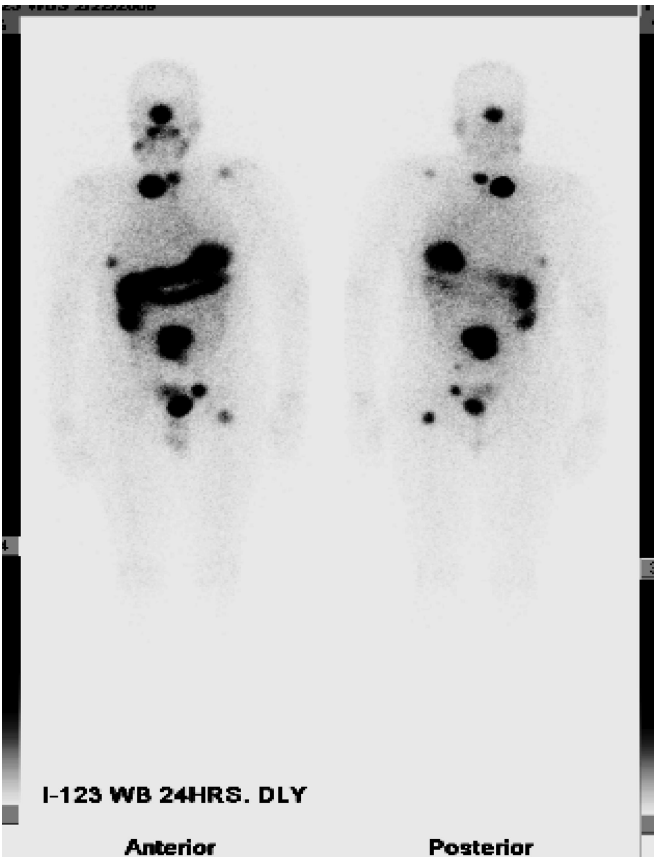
rhTSH-stimulated ¹²³I DxWBS scan in a 49-year-old man (case number 7, Table 3) showing abnormal uptake consistent with widespread skeletal metastases involving the skull, T2 vertebral pedicle, third right rib (with soft-tissue component seen on corresponding CT scan), left seventh rib, dorsal spine, left shoulder, lumbar spine, sacrum, and proximal left femur.
